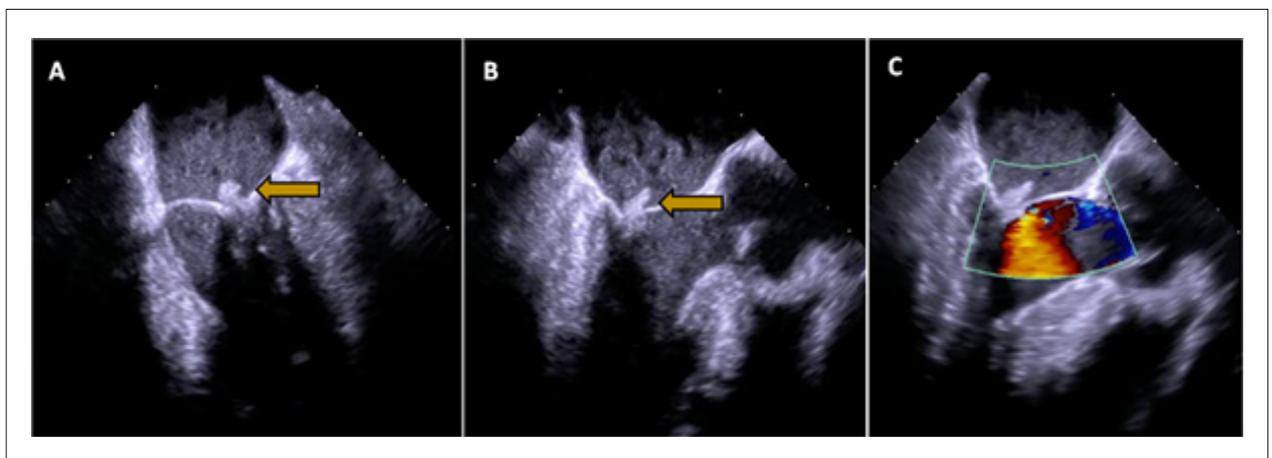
Initial transesophageal echocardiography performed during hospital stay. It revealed a large, filiform and mobile mitral vegetation (maximum diameter of 23 mm), attached to the atrial surface of the posterior mitral leaflet, involving P2 and P3 scallop regions (yellow arrow); TEE longitudinal view at 60° (A) and at 120° (B). No scallops prolapse or mitral regurgitation were evident (C).
